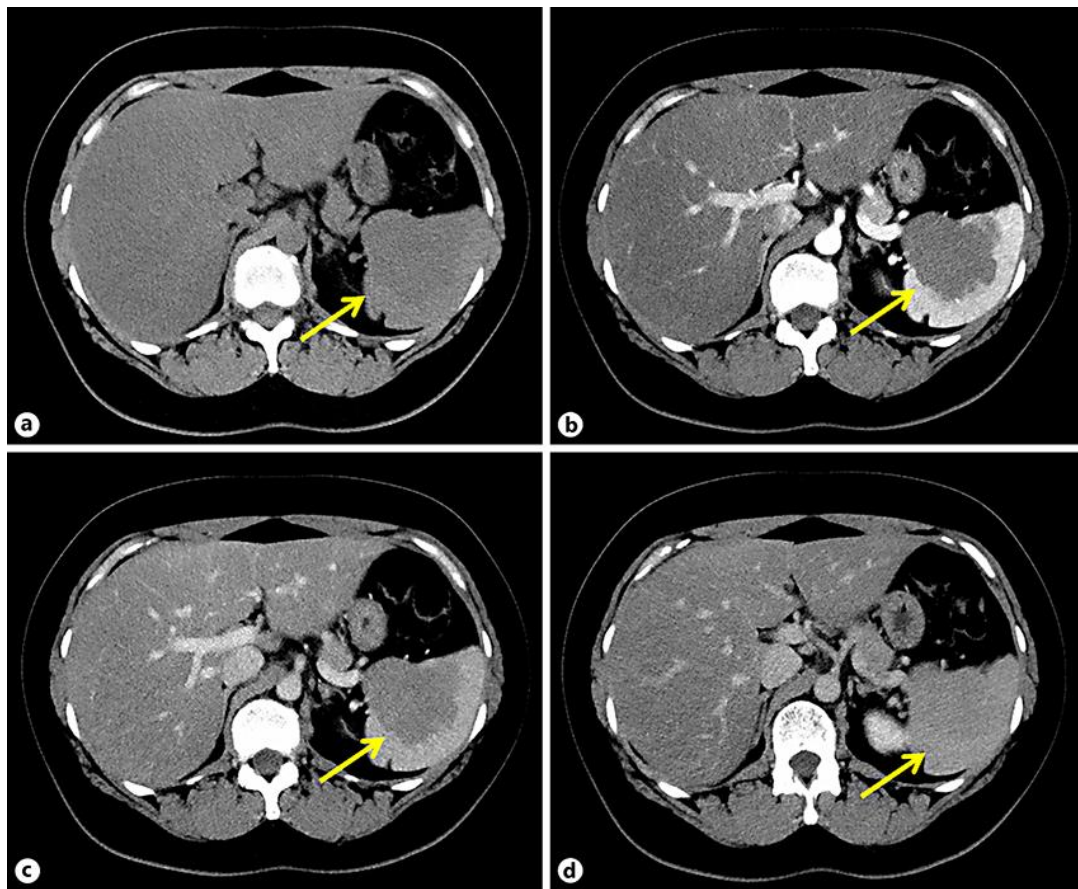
Dynamic computed tomography of the spleen. A gradually enhancing mass (65 × 65 × 55 mm) is observed in the spleen (arrow). No radial visualization of the inside of the tumor is observed. a Simple phase. b Arterial phase. c Portal vein phase. d Equilibrium phase.
